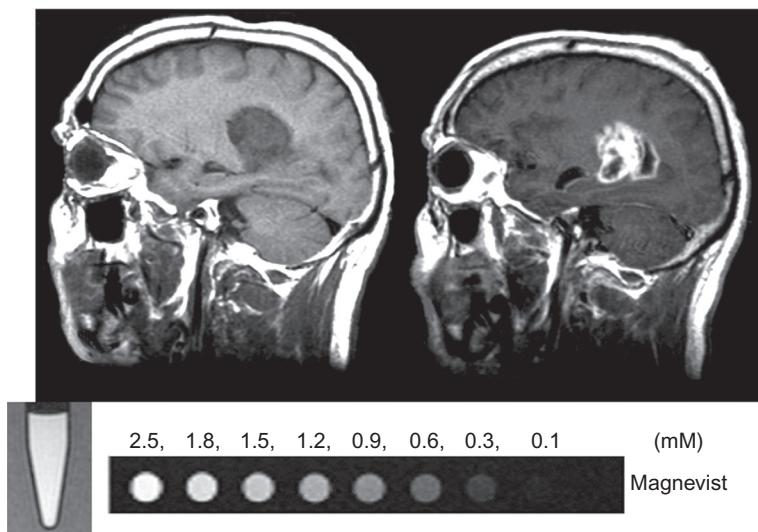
Upper image: MR-T₁ images of a glioblastoma patient before and after Gd injection. Notice the contrast enhancement due to the large magnetic moment of Gd (available in <http://home.physics.wisc.edu/gilbert/radio.htm>). Down: different concentrations of Magnevist as common MRI contrast agents.
